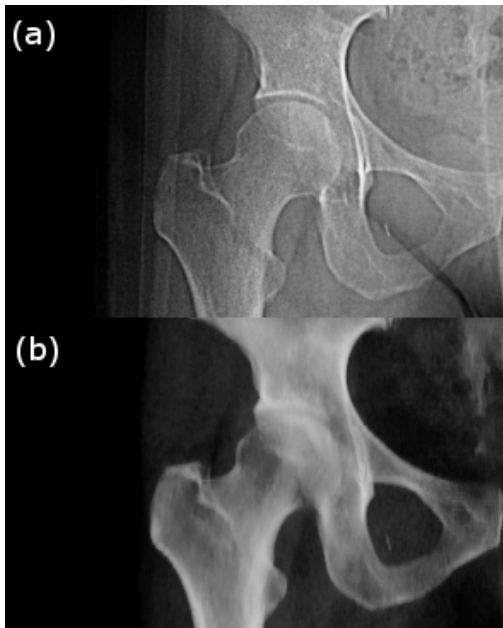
(a) Radiograph of a patient's femoral head (b) DRR of the same patient's femoral head with soft tissue subtracted
